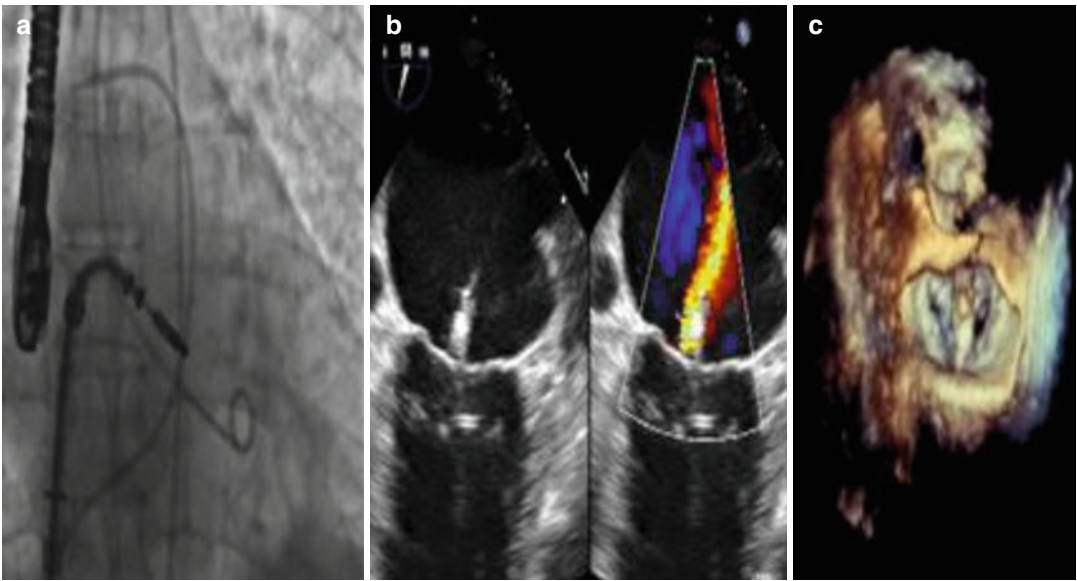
(a–c) MitraClip placement under angiography with follow up 2-D and 3-D echocardiograms (Modified from [23])
